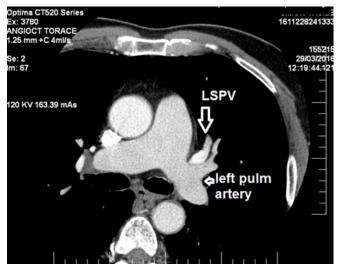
Computed tomography of the heart. Relationship between the pulmonary artery and the pulmonary vein. LSPV and left pulmonary artery can be seen together and sometimes it is difficult to differentiate them. The density of the contrast substance.
